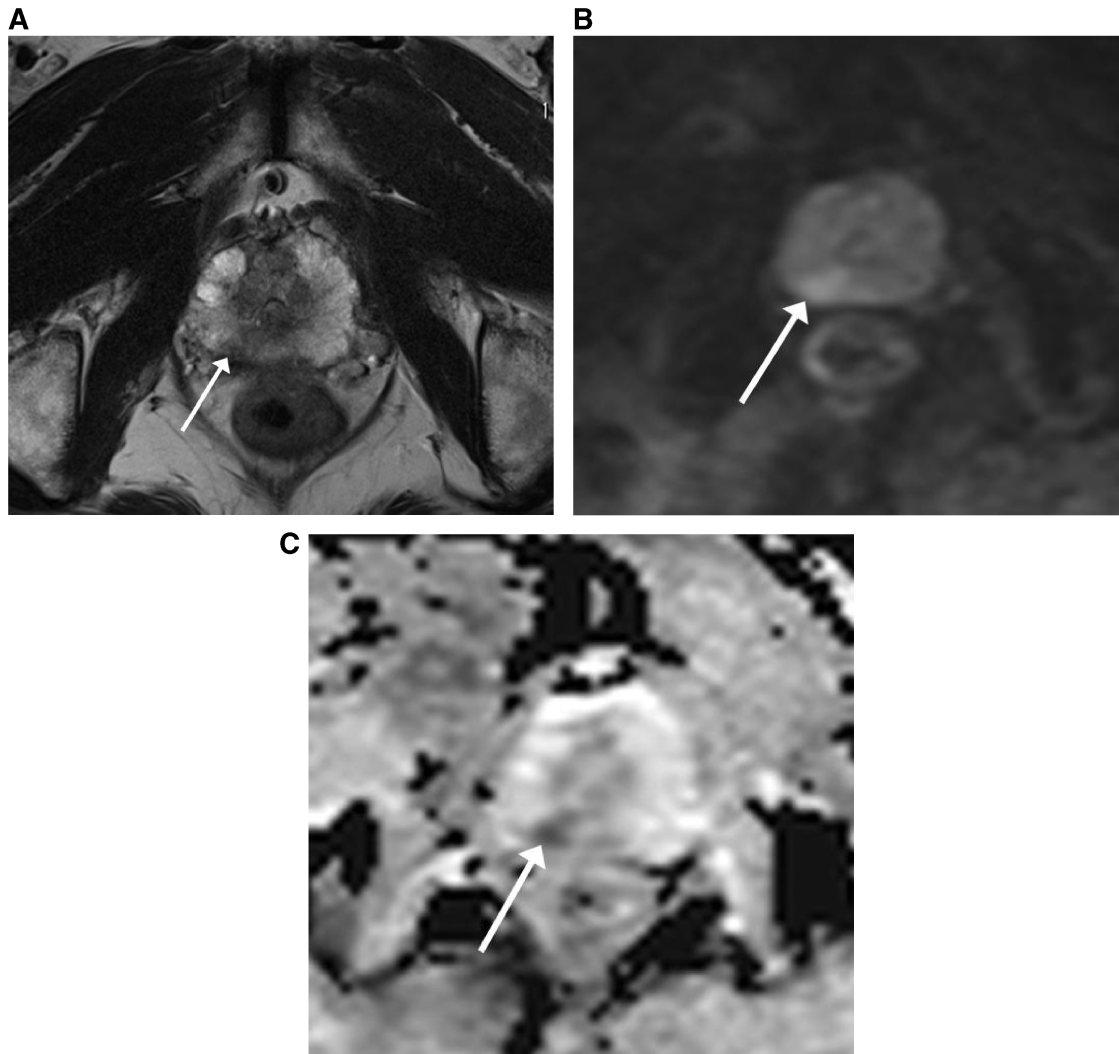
MRI (at 3 T) of a 69-year-old patient with a prostate carcinoma in the PZ on the right side (arrow). (A) On the axial T2-weighted MR image the tumour is visualized as an area of low signal intensity (arrow). (B) On the DW-MR image at a b value of 1000 s/mm^2 the tumour is not clearly visualized because of the T2 shine-through effect in the PZ of the prostate. (C) On the ADC map the tumour is clearly visualized as an area of impeded diffusion, represented by colour shades of dark grey, in contrast with the normal PZ of the prostate, which returns colour shades of light grey.
